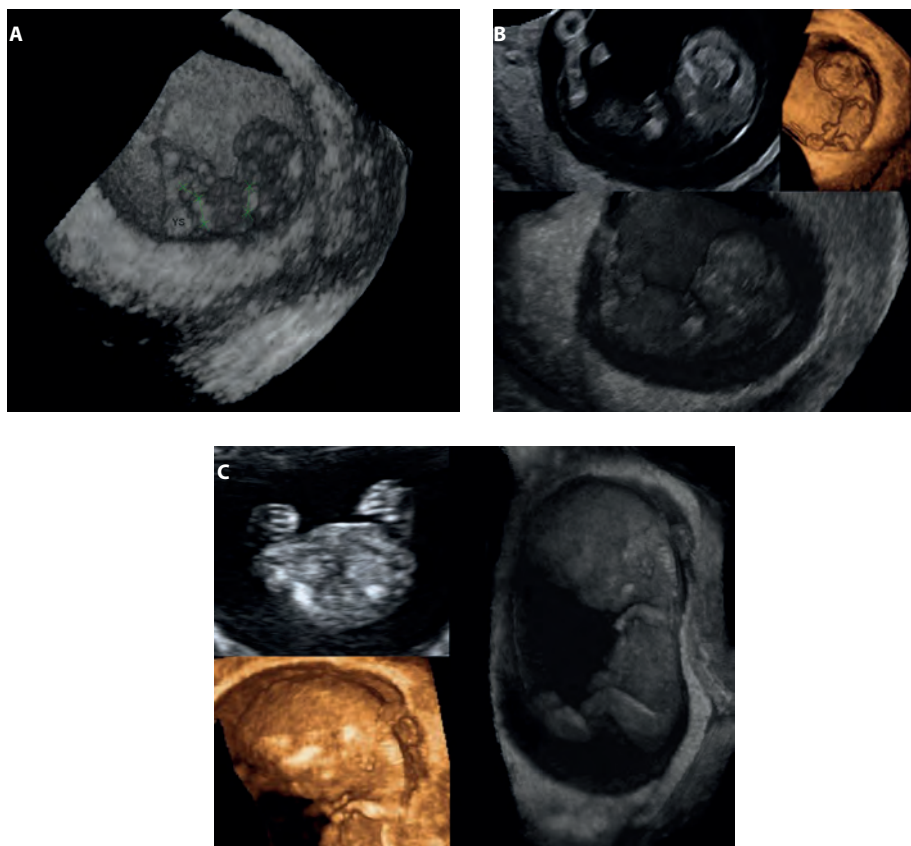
Patient with thrombocytopenia-absent radius syndrome showing (A) normal lower limbs and short upper limbs are seen using the I-Space virtual reality system at a gestational age (GA) of 9+1 weeks, (B) abnormal upper limbs with absent radius on two-dimensional and three-dimensional ultrasonography and using virtual reality at 10+1 weeks GA, and (C) the presence of both thumbs and abnormal ears at 11+1 weeks GA.
